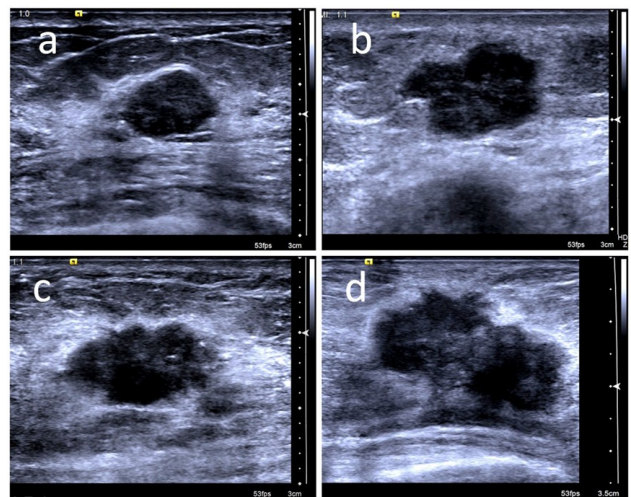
Comparison of the ultrasound features of breast cancer masses with different tumor sizes. The ultrasound image of a breast cancer mass of 11 mm diameter from a 40-year-old woman was diagnosed as BI-RADS 3 category according to the characteristics of hypoechoic, circumscribed margin, oval shape, parallel growth orientation and calcification negative (a). The ultrasound image of a larger breast cancer mass (diameter = 18 mm) in a 48-year-old woman was diagnosed as BI-RADS 4a category based on the positive characteristic of irregular shape (b). The ultrasound image of a breast cancer mass of 22 mm diameter from a 45-year-old woman was diagnosed as BI-RADS 4b category according to two positive characteristics of irregular shape and calcification (c). The ultrasound image of a larger breast cancer mass (diameter = 32 mm) in a 56-year-old woman was diagnosed as BI-RADS 4c category. according to three positive characteristics of irregular shape, calcification and spiculated margin (d).
